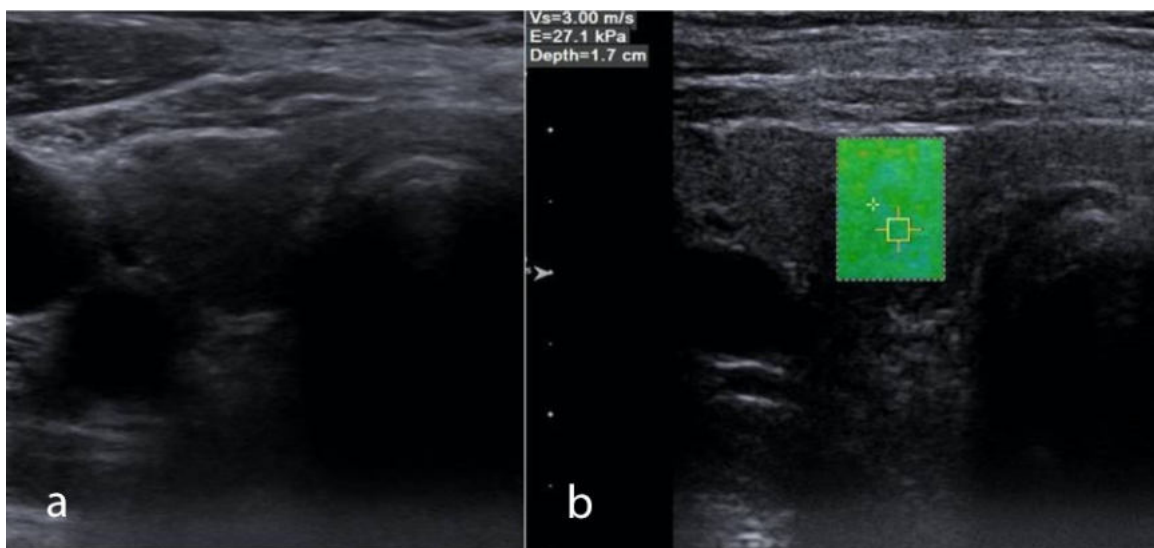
(A) On B mod ultrasonography, the largest area in the thyroid right lobe in axial plan, (B) Measurement made with SWE in the largest region in the axial plan.
